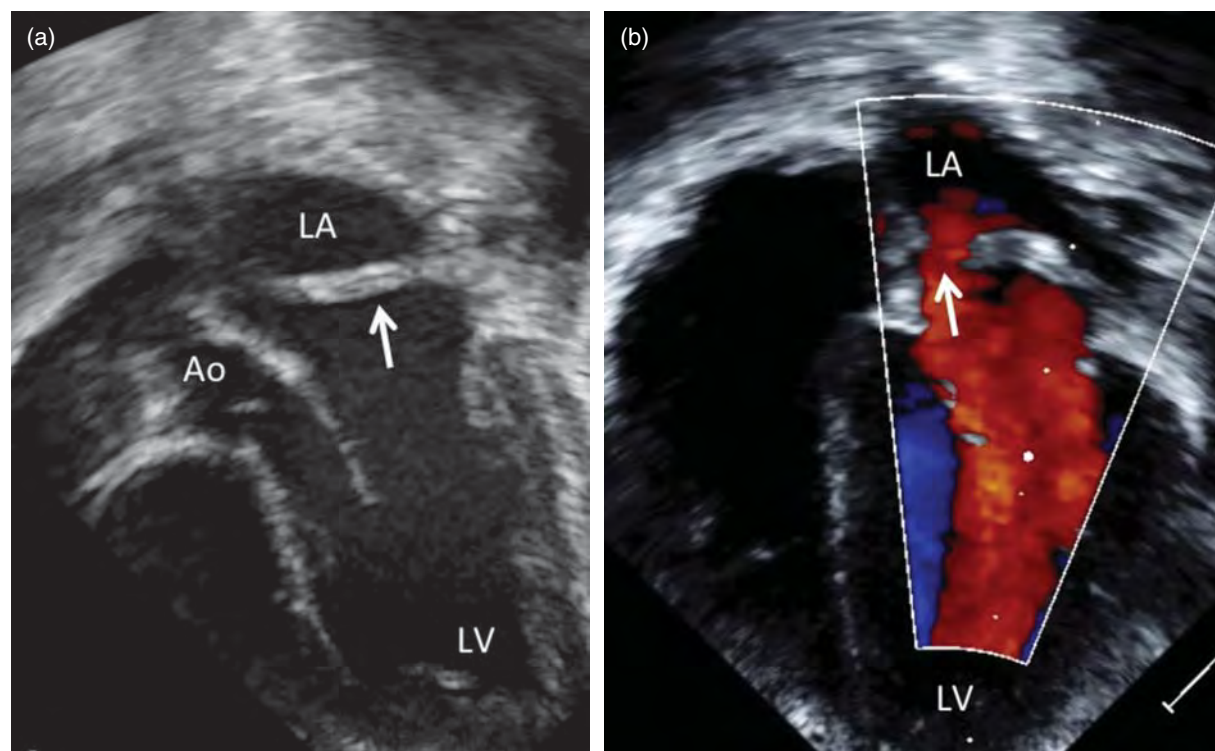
Echocardiography images demonstrating cor triatriatum sinister. (a) Anatomic features of cor triatriatum as seen from a "five chamber" view. The thick fibromuscular membrane within the left atrium is seen (arrow) dividing the left atrium into two chambers. (b) Using color flow mapping, the defect within the fibromuscular membrane is seen with flow between the distal and proximal chamber seen (arrow). Ao, aorta; LA, left atrium; LV, left ventricle.
